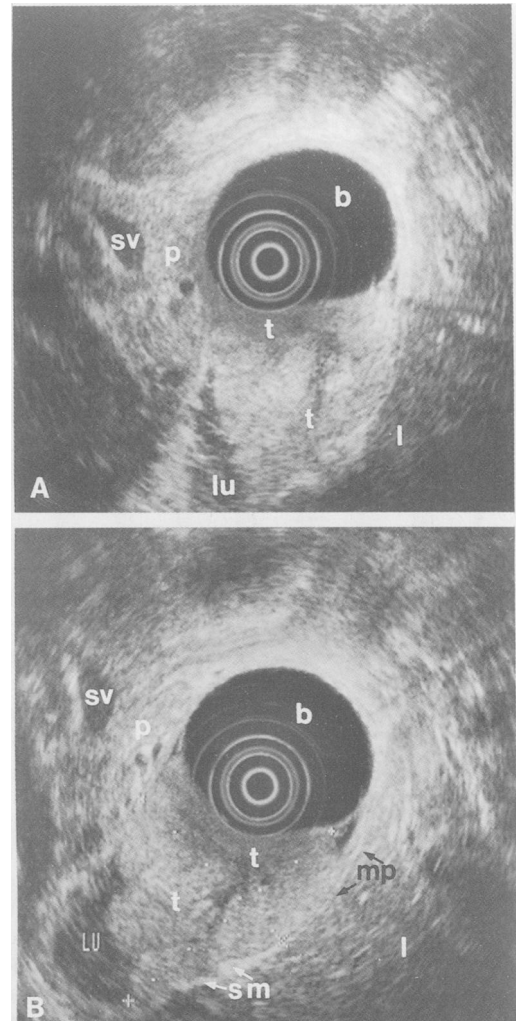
(A): Endosonogram showing an exophytic duodenal tumour (t) adjacent to the left liver lobe (l) contralateral to the pancreas (p). b=water filled balloon, lu=water filled duodenal lumen, sv=splenic vein. (B) Another cross section shows the exophytic duodenal tumour (t) without penetration into the submucosa (sm) and muscularis propria (mp). b=water filled balloon, lu=water filled duodenal lumen, sv=splenic vein, p=pancreas, l=left liver lobe.
